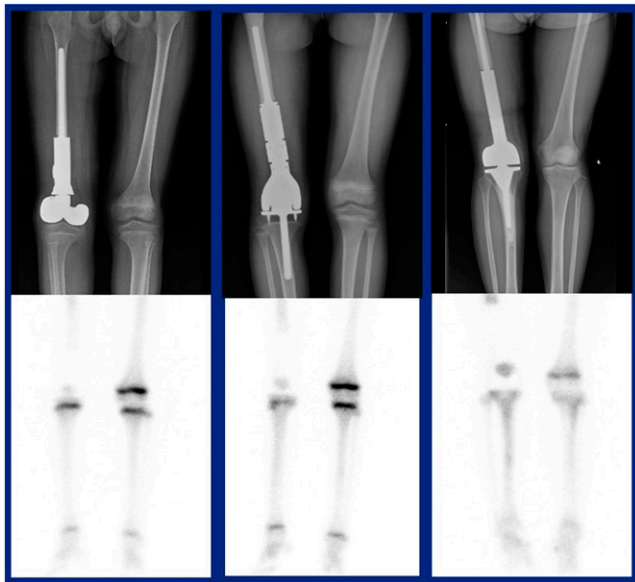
^{99m}Tc -MDP bone scintigraphy and epiphyseal uptake for tibial growth potential in endoprostheses after malignant bone tumors. Images were acquired in (left to right) hemiarthroplasty, simple-hinged endoprostheses, and adult-type rotation-hinged prostheses, with normal ^{99m}Tc -MDP uptake maintained in 66%, 5.6%, and 0%, respectively.
